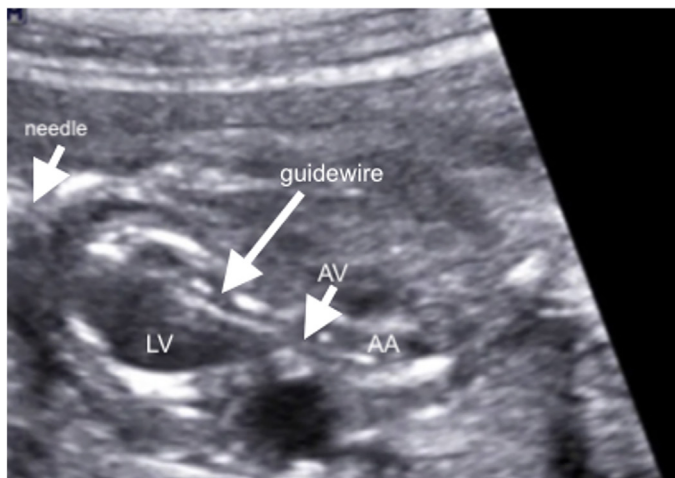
Ultrasound view showing an 18-G needle passing through the maternal abdomen, uterus, fetal anterior chest, and left ventricular apex (24). The coronary guidewire was advanced through the needle, passing through the aortic valve and ascending aorta. LV: Left ventricular, AV: Aortic valve, AA: Ascending aorta
